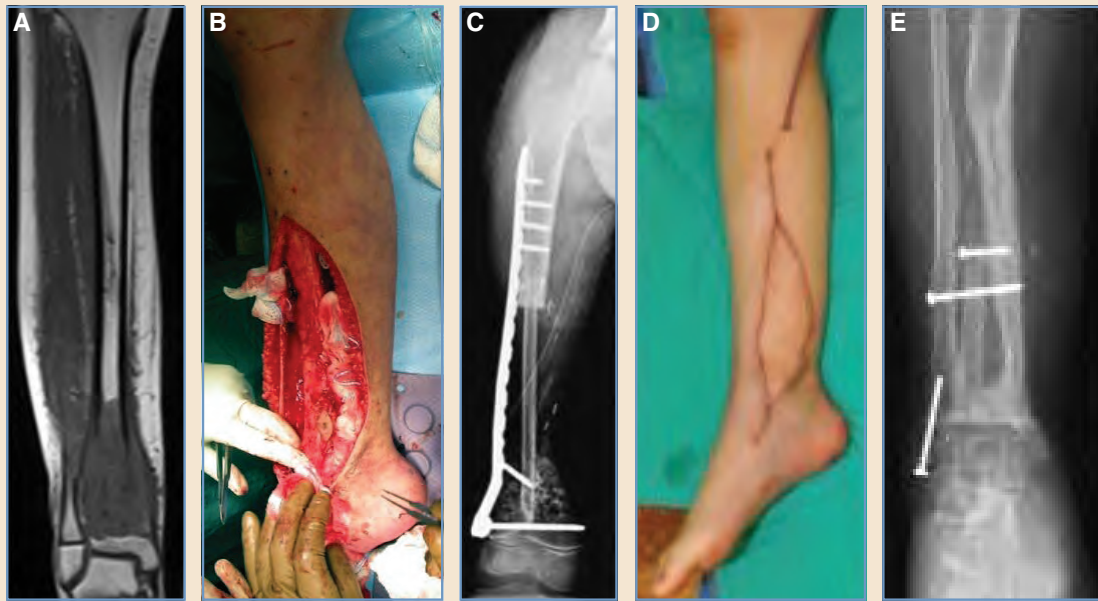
This patient had malignant bone tumors amenable to intercalary resection and reconstruction with a vascularized fibula flap. A, Preoperative MRI showed a tumor of the distal tibia. B, An intraoperative view after the tumor was dissected free and ready for removal. C, A postoperative radiograph showed the transferred contralateral fibula in place. D, An intraoperative view at the completion of the osteocutaneous fibula flap transfer. E, A radiograph obtained 2 years after the transfer shows excellent bony healing proximally and distally and interval hypertrophy of the transferred fibula.
